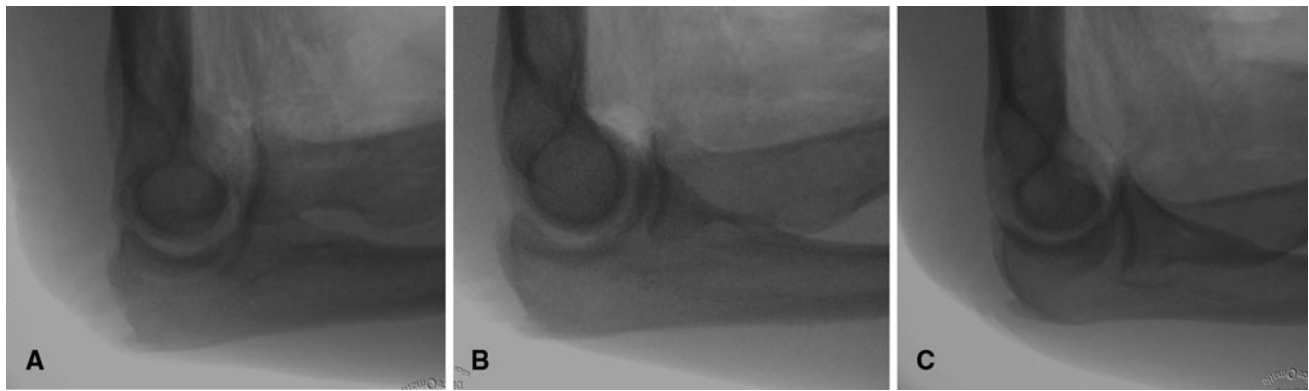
Radiographs of (A) a nonsubluxated elbow with 20° inferior beam angulation, and (B) the same nonsubluxated elbow in neutral position, and (C) with 20° superior beam angulation are shown.
